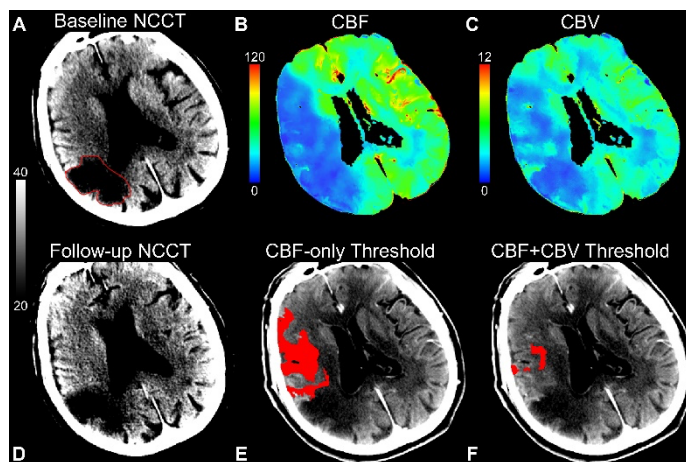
CBF-only and CBF+CBV thresholding to predict baseline infarction. (A) Baseline non-contrast CT (NCCT) showing a chronic infarct (red outline); (B) CBF and (C) CBV maps; (D) Twenty-four-hour follow-up NCCT showing no new acute infarction; (E) CBF-only threshold infarct; (F) CBF+CBV threshold infarct. Chronic infarction was excluded by thresholding dynamic CT perfusion images. The CBF-only threshold estimated an infarct volume of 44.3 ml (ghost core), while the CBF+CBV threshold estimated 9.8 ml (non-ghost core). False positives from CBF+CBV thresholding were primarily in the white matter, which inherently has lower CBV.
